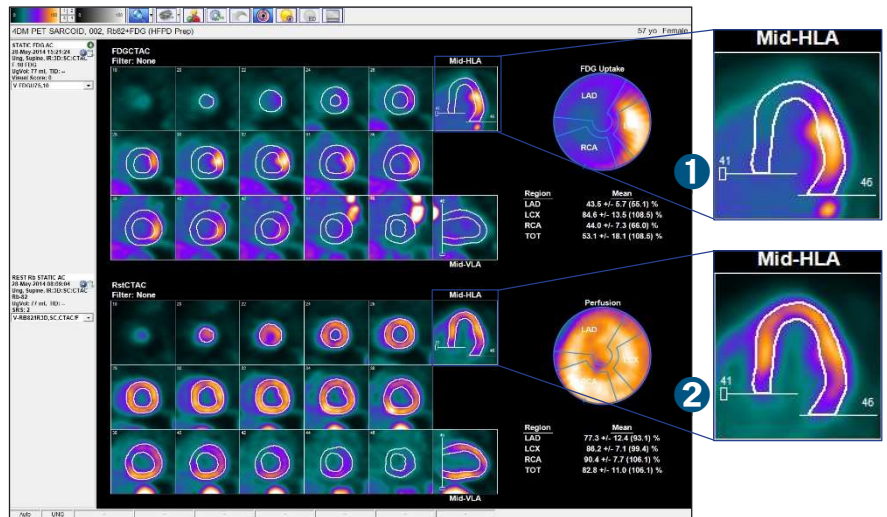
MI Processing screen with F-18 FDG on top and Rb-82 on bottom
